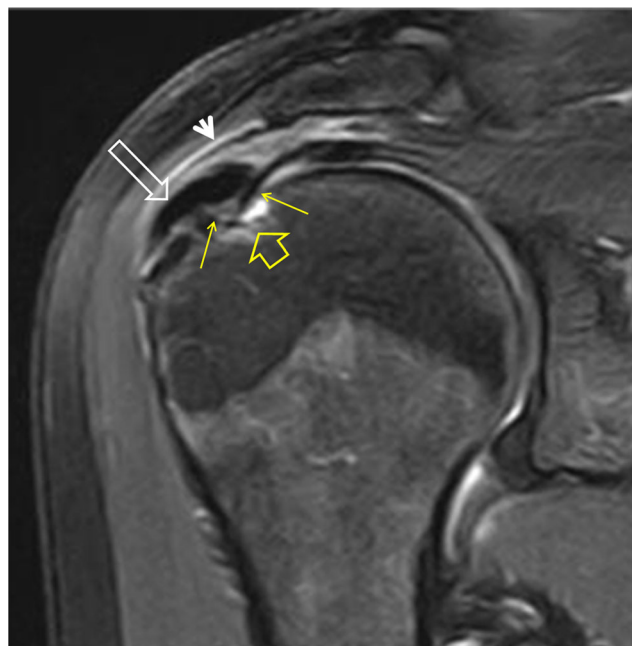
A 50-year-old male patient with a 5-month history of pain. The fat-suppressed oblique coronal PD-weighted MRI shows the intratendinous calcification (long open arrow), the cortical irregularity (arrows), the subcortical cyst and reactive marrow oedema (short open arrow), and the subacromial bursitis (arrowhead)
